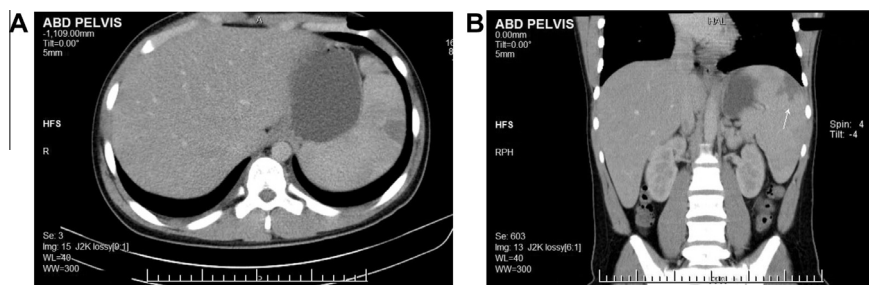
(A and B) 16-year-old male with acute left upper abdominal pain. Axial (A) coronal (B) CT reformation of MDCT scan with oral and I.V. contrast shows mildly enlarged liver and spleen with wedge-shaped supracapsular non-enhanced hypodense area at the diaphragmatic surface of the spleen consistent with splenic infarction.
